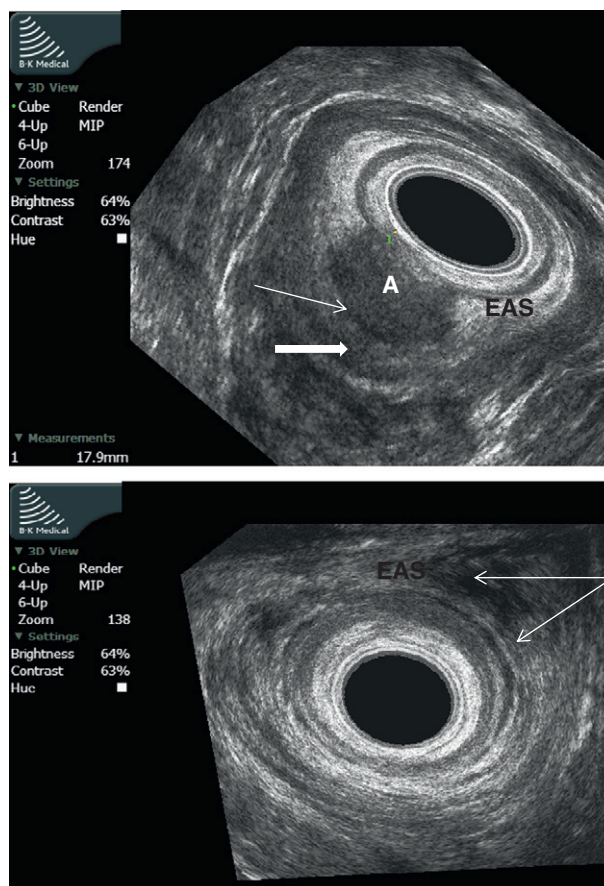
Top image 3-dimensional axial image of the Crohn's Ultrasound Fistula Sign (CUFS) showing an abscess collection (A) crossing the external anal sphincter (EAS) flanked by a hypoechoic edge (arrow) and a surrounding hyperechoic rim (black arrow). This is distinct from the appearance of a cryptogenic fistula (bottom image) where the fistula track (arrows) shows no hypo- or hyperchoic rims, appearing as a simple hypoechoic track traversing the external anal sphincter (EAS).
